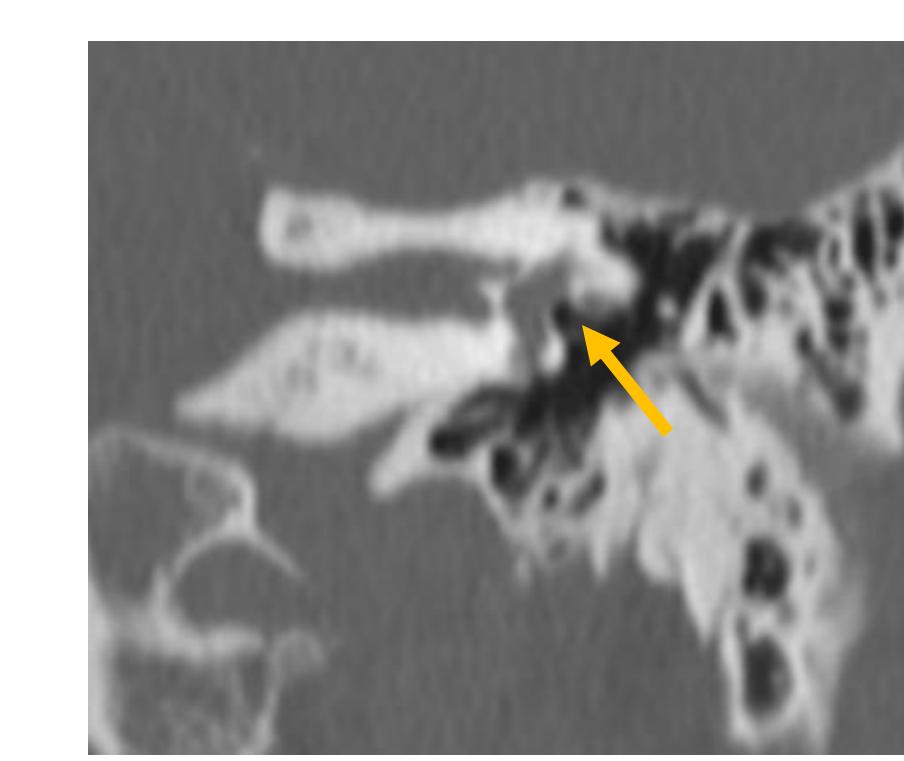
Axial CT in this patient with otosclerosis shows bony overgrowth causing severe stenosis of the round window (arrow).
